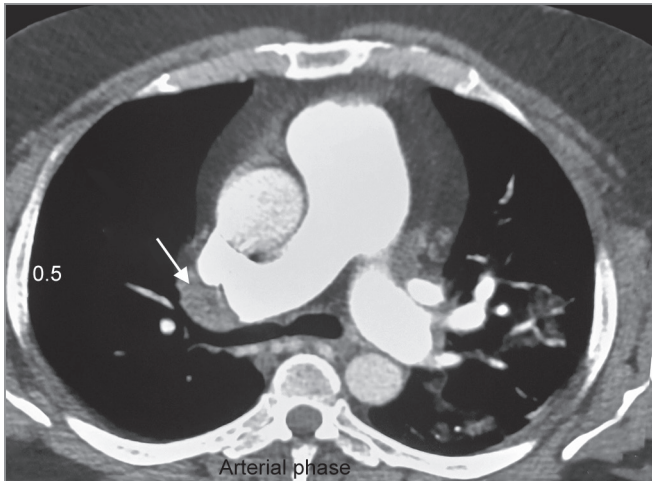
CT pulmonary angiography showing large embolus in right pulmonary artery (arrow)
